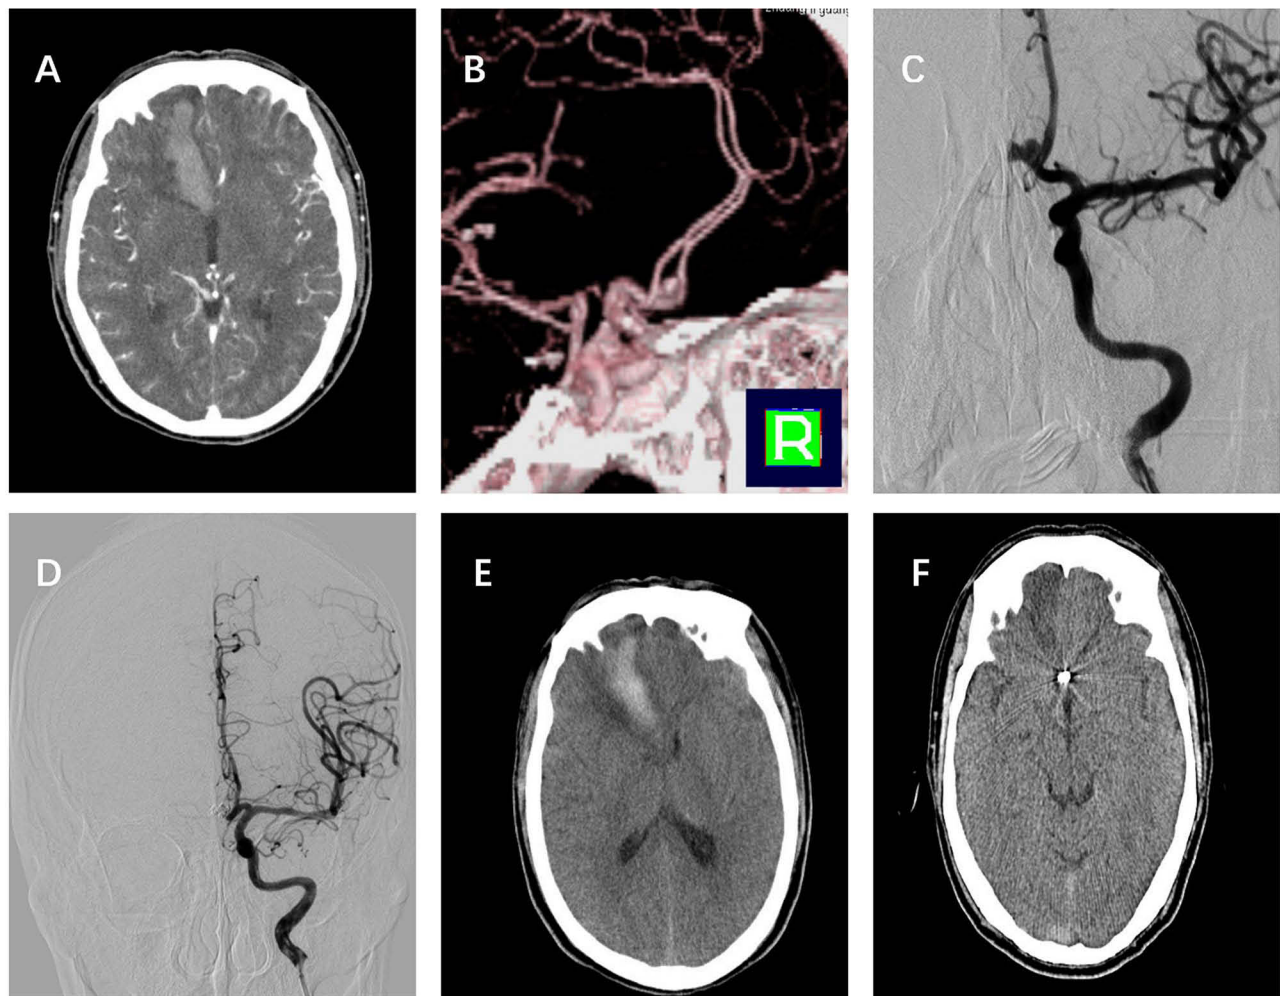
(A–C): CTA and DSA demonstrated a ruptured AcomA aneurysm with intracerebral hematoma (23.5mL). (D and E): The aneurysm was embolized and hematoma was preserved. (F): Hematoma was completely absorbed 3 months after surgery and without cerebral infarction.
